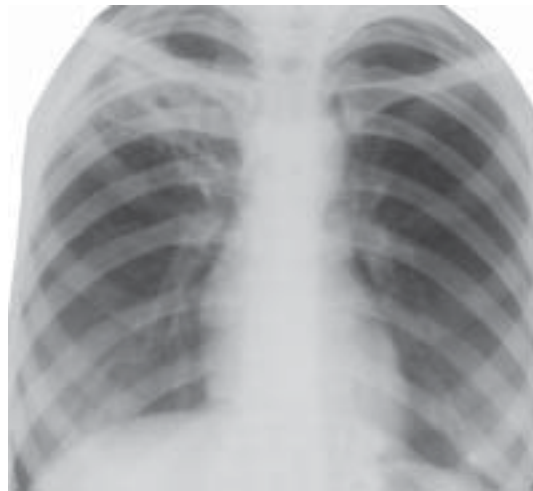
Infiltrative tuberculosis of the right lung upper part, decay phase. Artefact above the diaphragm left cupola. Observation roentgenogram.
